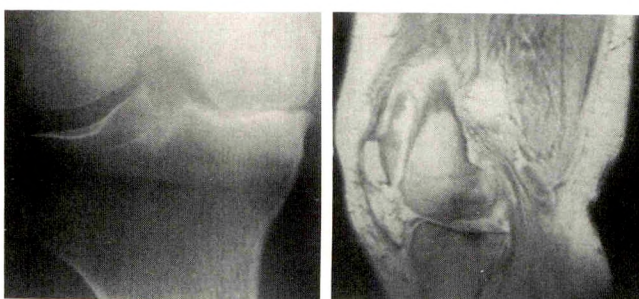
MR imaging of osteoarthritis of knee.
